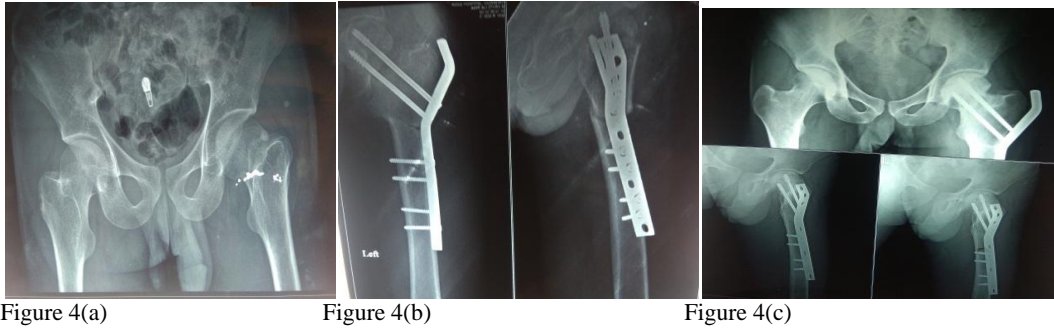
(a) 27 year old male patient. Figure 4(b) Modified valgus osteotomy was done and fixed with double angled DCP. Figure 4(c) Complete union at fracture site and osteotomy site is noted in follow up xray at 6 months.
